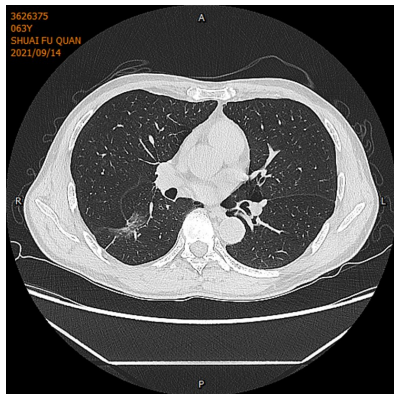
Axial CT scan post-biopsy showing the position of the needle tract and changes in the nodule's surrounding lung parenchyma.
